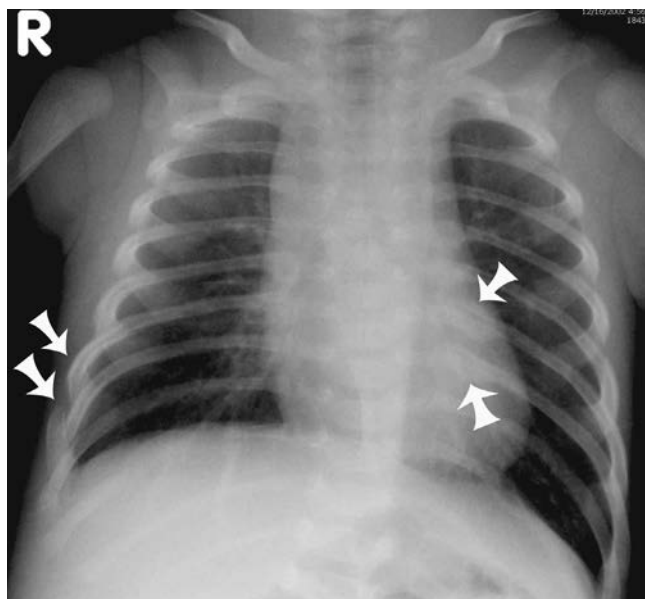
Rib fractures in multiple stages of healing in a 4-month-old female victim of nonaccidental injury. Frontal chest radiograph reveals acute (no periosteal reaction or healing) and subacute/healing (positive periosteal reaction) rib fractures (arrows).
